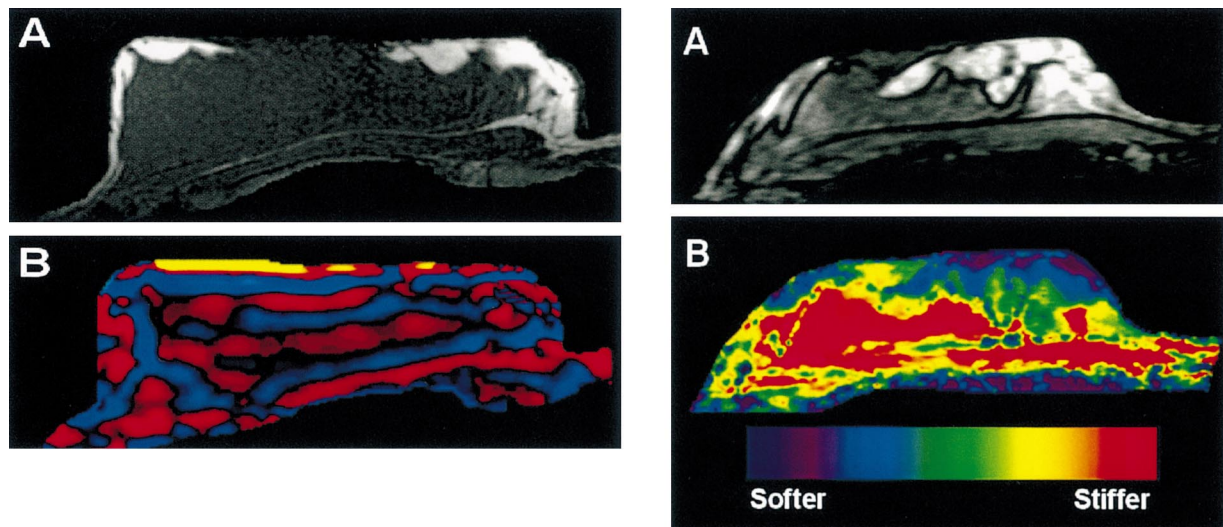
Left: (a) Axial T1-weighted spin-echo image of the breast of a volunteer with mostly fibroglandular tissue. (b) Wave image demonstrating propagating shear waves in the breast and chest wall. The image was obtained with shear waves at 100 Hz applied to the anterior part of the breast. The motion is in and out of the plane and the waves are propagating toward the chest wall. Right: (a) Axial T1-weighted spin-echo image of the breast of another normal volunteer with more adipose tissue. (b) MR elastogram obtained for this volunteer with shear waves at 100 Hz applied to the anterior part of the breast. The elastogram depicts clear differentiation between soft adipose tissue and stiffer fibroglandular tissue.
